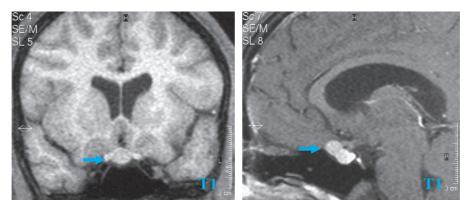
Pituitary Gd enhance MRI (Case 2)
